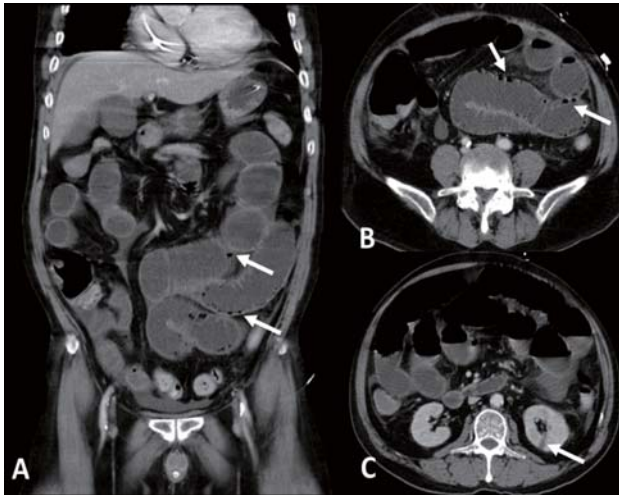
(A) Coronal and (B) sagittal views of contrast-enhanced computed tomography of abdomen demonstrated long segmental dilated small bowel loops with pneumatosis intestinalis (white arrows). (C) A wedge-shaped area with poor enhancement over lower pole of left kidney (white arrow) was noted.
